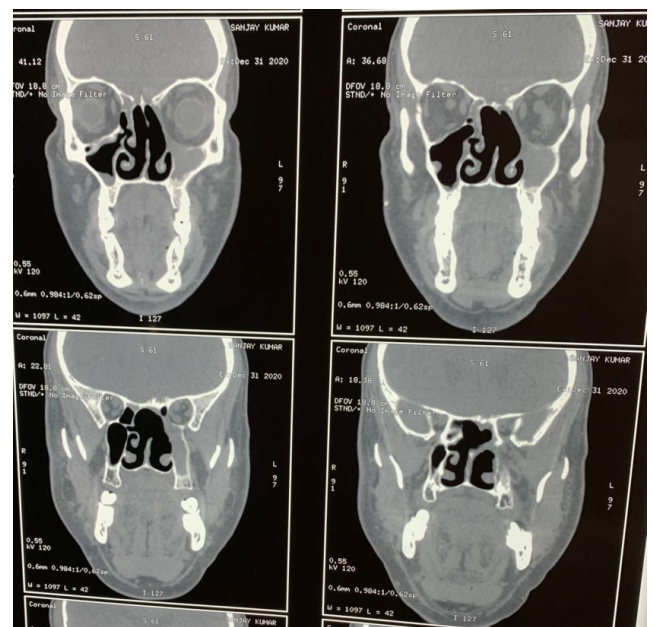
CT scan of the paranasal sinuses repeated 6 months after the surgery showing complete resolution of mass.
